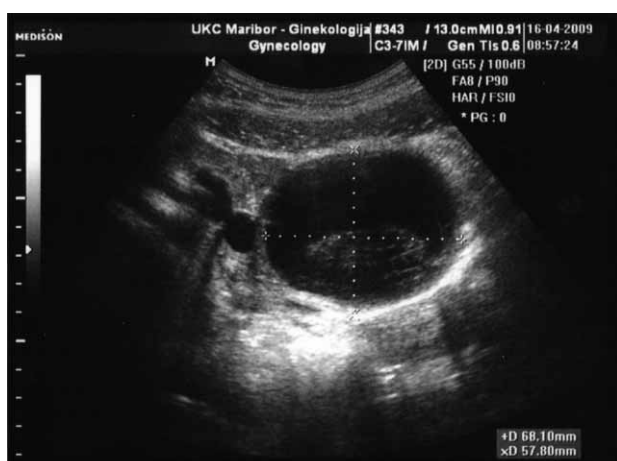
Ultrasound imaging of pelvis showing hypoechoic cystic formation 64×56 mm in the right ovary with irregular echogenicity inside and highly vascularized cysts inside and highly vascularized cysts inside and highly vascularized cysts inside.
